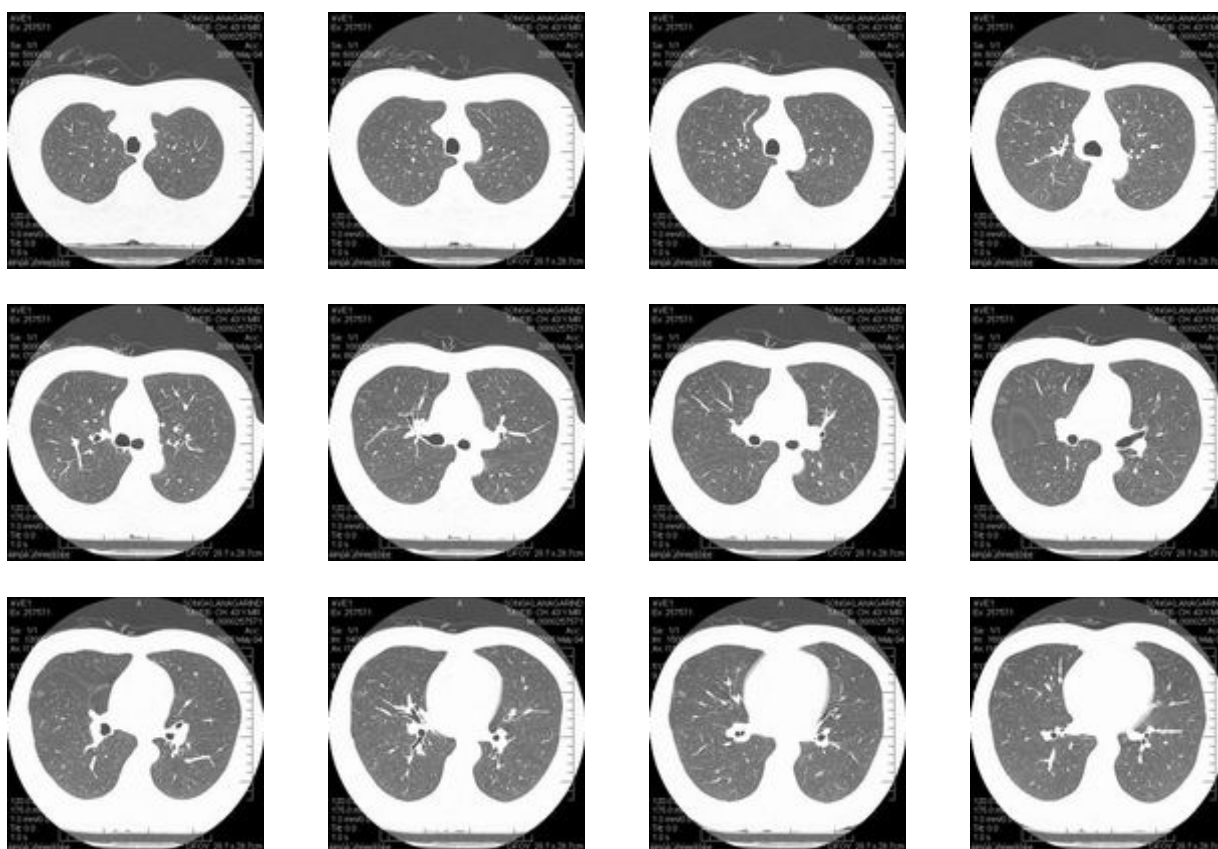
Example of a worker's HRCT scan (negative finding).
